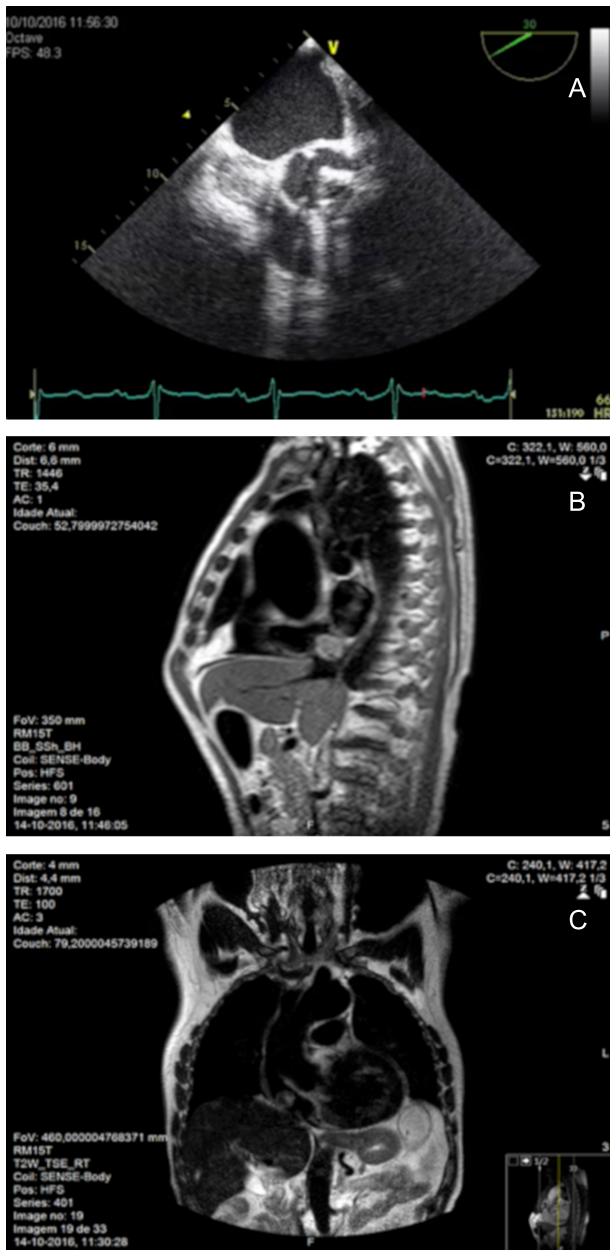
Transesophageal echocardiography (panel A) and cardiac magnetic resonance (panels B and C).
